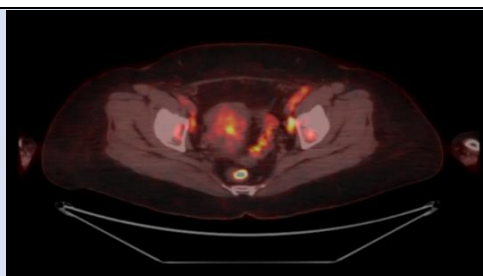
FDG PET/CT scan image, axial view at bilateral external iliac level shows FDG hypermetabolism within the wall of bilateral external iliac vessels, likely represent sarcoid vasculitis.
